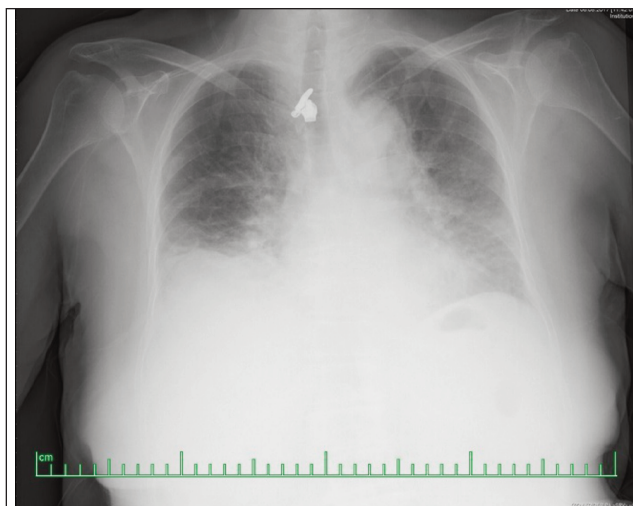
The initial chest radiograph showing pleural effusion on the right side.
